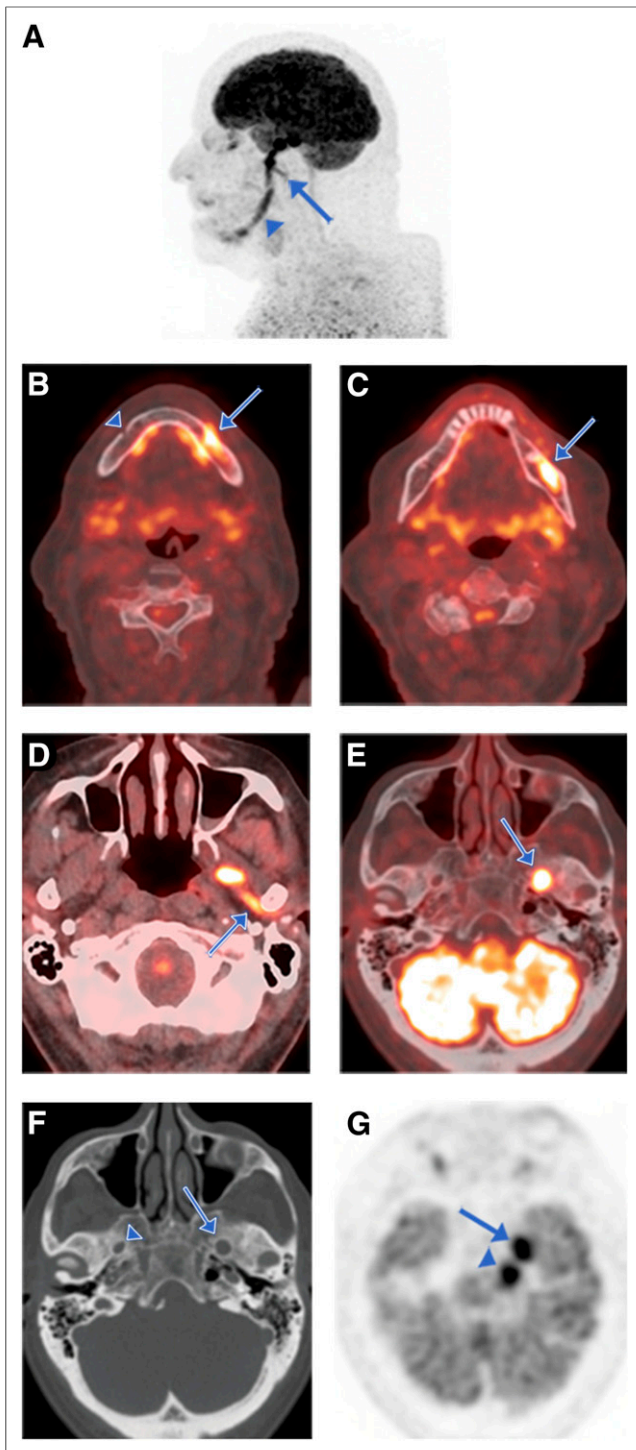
CN V3 (mandibular nerve, inferior alveolar and auriculotemporal branch) involvement in patient with recurrent desmoplastic melanoma of left lower lip presenting with left facial numbness. (A) Sagittal maximum-intensity-projection PET image shows ^{18}F -FDG-avid tumor spread along entire course of CN V3 (arrowhead) and along auriculotemporal branch (arrow). (B–G) Axial serial PET/CT and (F) axial CT images show ^{18}F -FDG-avid tumor entry at left mental foramen (arrow, B), in contrast to normal right mental foramen (arrowhead, B) and PNS along inferior alveolar nerve through mandibular canal (arrow, C), along auriculotemporal nerve (arrow, D), and then cephalad through left foramen ovale (arrow, E), which is enlarged (arrow, F) compared with normal contralateral side (arrowhead, F) on CT bone window. (G) Axial PET
